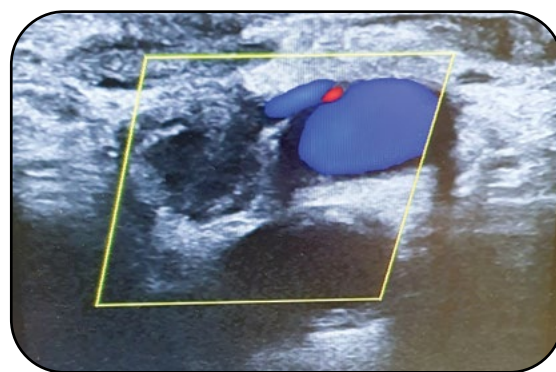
Vascular ultrasound: thrombus partially occupying the left common femoral vein
